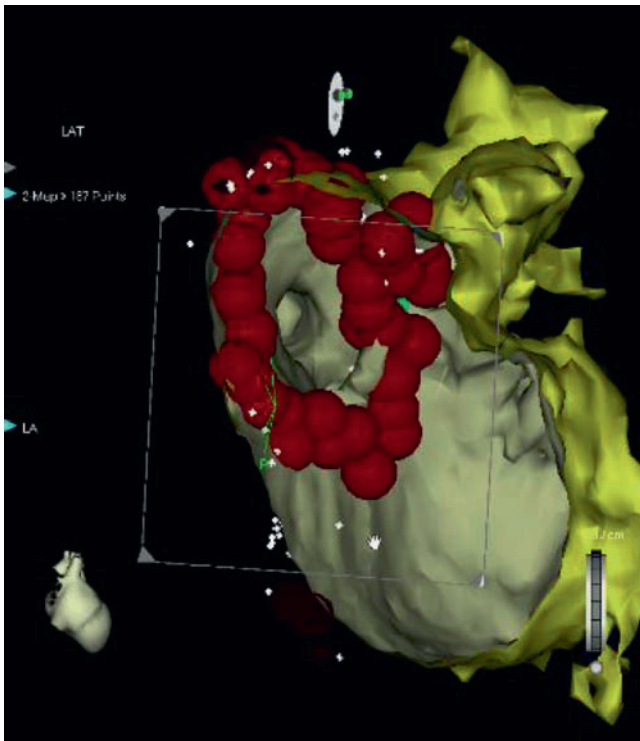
Image processing for electroanatomic mapping with CCTA image integration with a catheter-based anatomic map of the left atrium (a, upper image) and the 3-D volume rendered CT image of the left atrium (a, lower image) with integration of these images (b).
